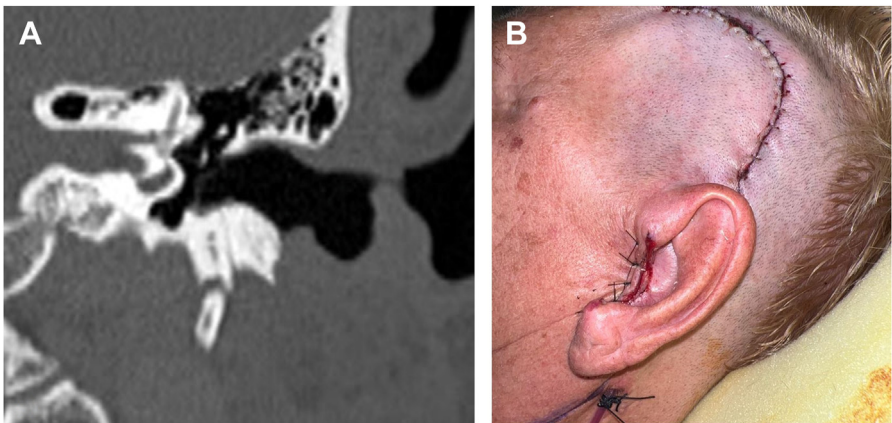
Preoperative CT temporal bone in the coronal plane (A), demonstrating left superior bony external auditory canal soft tissue thickening in a patient diagnosed with primary basal cell carcinoma of the external auditory canal. She underwent a left lateral temporal bone resection, external auditory canal closure and temporalis rotational flap (B).
